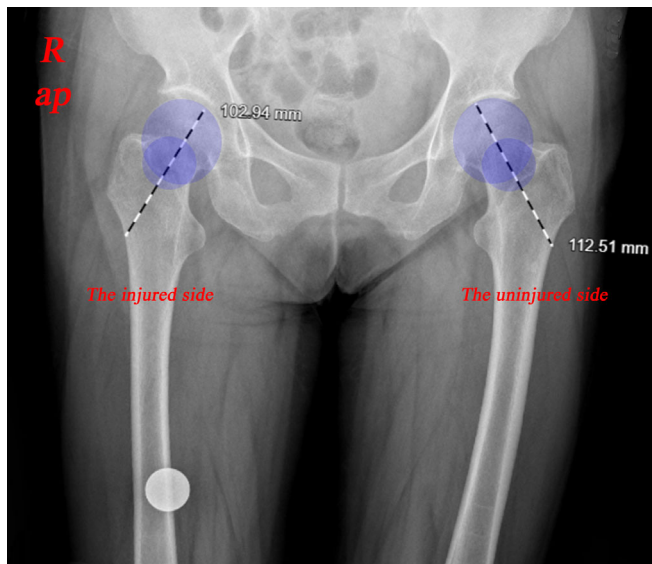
Measurement of femoral neck shortening on anteroposterior radiographs of the pelvis. Draw a line passing the center of the femoral head and the center of the femoral neck. The length of line segment is from vertex of femoral head to lateral wall of femur. The femoral head shortening is defined as difference between the uninjured side and the injured side
